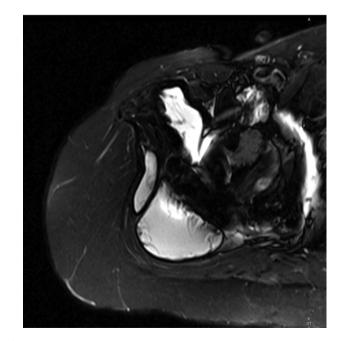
Pre-operative magnetic resonance imaging: axial T2 magnetic resonance imaging with hyperintense, complex, multiloculated, and heterogeneous cystic soft tissue tumor involving the right hip abductors. The pseudotumor measured $4.4 \times 6.2 \times 10$ cm at its largest dimension.
